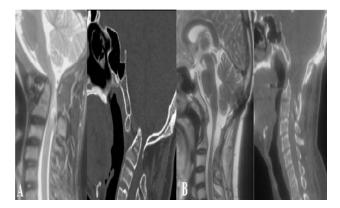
A) Preoperative MRI T2 weighted sagittal section of cervical spine and CT cervical spine sagittal section showing atlantoaxial dislocation compressing the CVJ ventrally causing T2 weighted changes of the cord. B) Postoperative CT and MRI cervical spine showing reduction of AAD with restoration of normal alignment. Note: The postoperative MRI cervical spine is showing adequate decompression of the cervical cord with widening of dorsal and ventral subarachnoid spaces.
